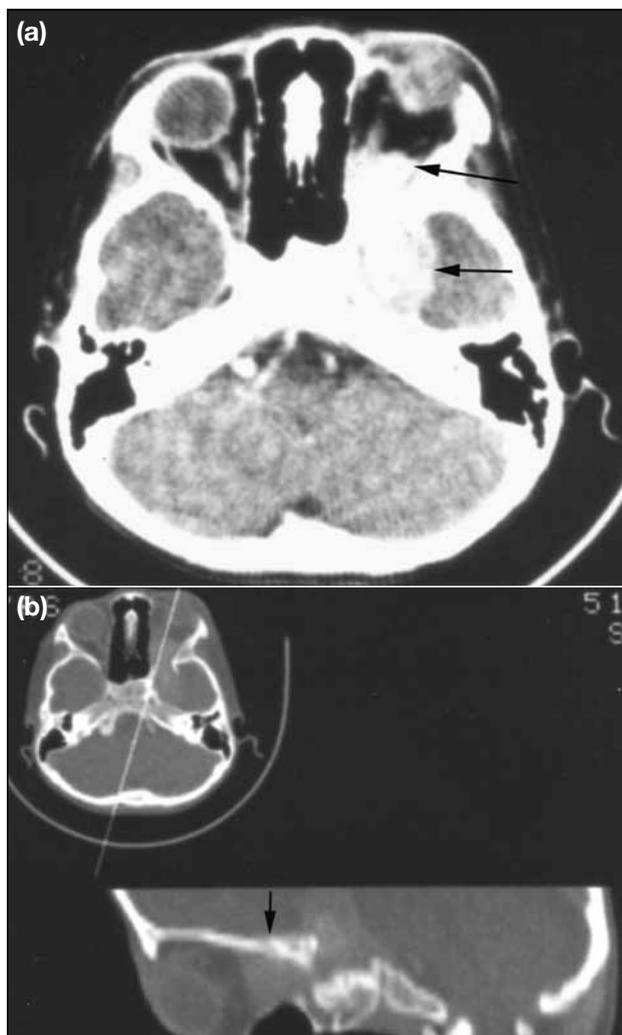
(a) Axial computed tomography through the skull base shows a well-defined uniformly enhancing mass along the left sphenoid wing and spreading to the retro-orbital space and left cavernous sinus region (arrows). Note left proptosis. (b) Sagittal reconstruction along the left orbital axis using a bone algorithm re-demonstrates the extent of posterior orbital involvement. Increased bone density is present in the medial sphenoid wing (arrow).
